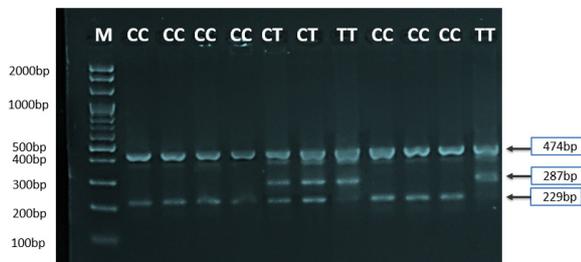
Agarose gel electrophoresis image that showed the T-ARMS-PCR product analysis of IL-13 rs1800925 C/T-1055 gene polymorphisms. Where M: marker (2000-100bp). The lane (CC) wild type homozygote was showed C allele at 229bp T-ARMS-PCR product. The lane (TT) mutant type homozygote was showed T allele at 287bp T-ARMS-PCR product, whereas the (CT) heterozygote were showed as both C and T allele at 229bp and 287bp T-ARMS-PCR product. The outer internal control was observed at 474bp T-ARMS-PCR product.
